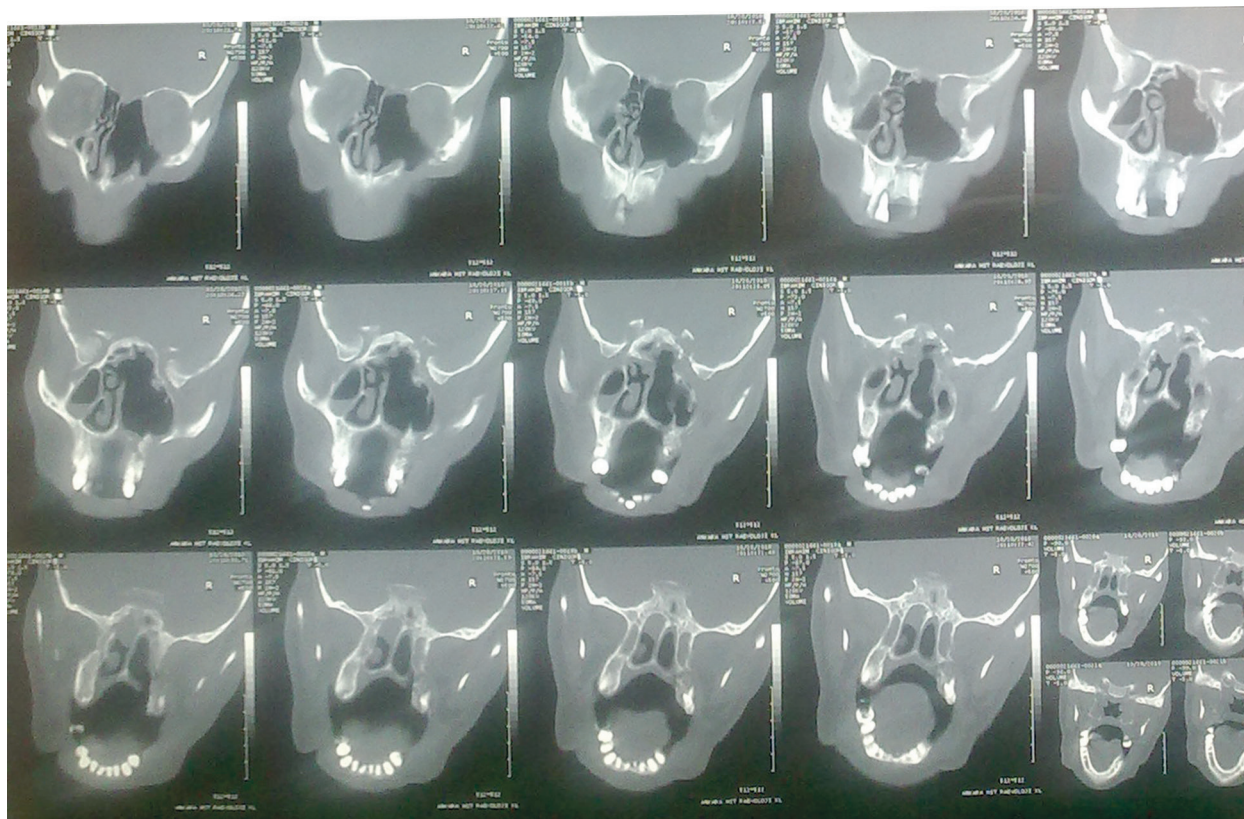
Preoperative Computed Tomography image
